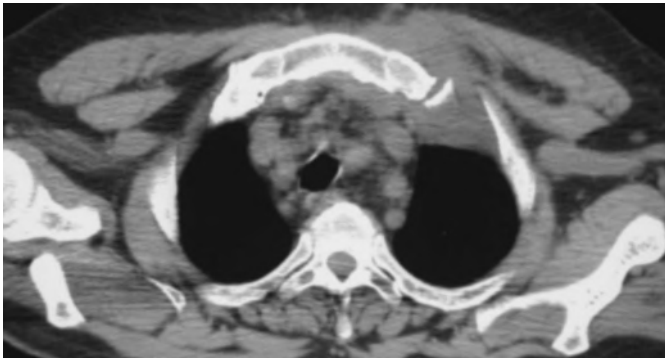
2b (axial CT scan, at the level of the lung apex): A not well demarcated mildly inhomogeneous soft tissue mass with extension into the left anterior chest wall and displacement of the left pectoralis major muscle anteriorly, is present. Inside the lesion calcifications are visible. After intravenous administration of iodinated contrast medium the lesion enhances homogeneously. Note that sternum is thickened.
